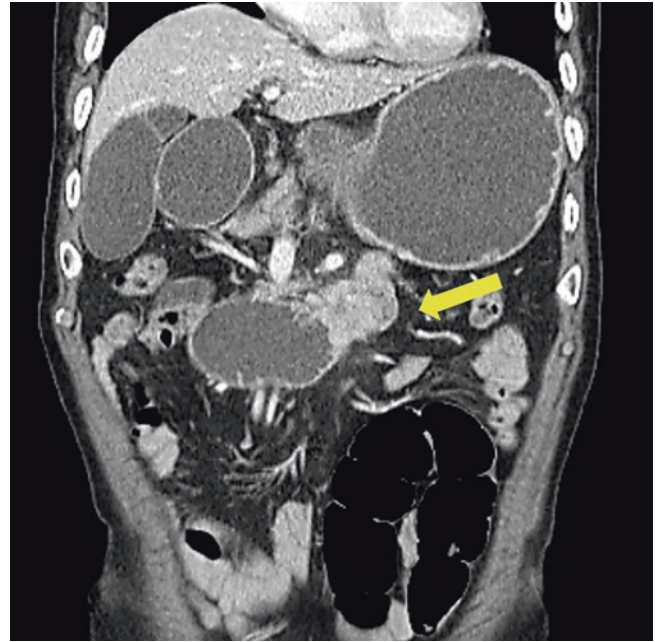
Duodenal adenocarcinoma. Computed tomography shows infiltrative heterogeneous enhancing mass in the distal fourth portion of duodenum adjacent to the Treitz ligament (yellow arrow)
